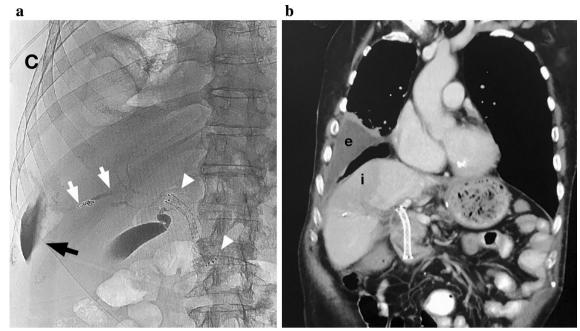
a Final image post-stent placement (white arrowheads) and tract sealing (white arrows). Black arrow points at the opacified right pleural sulcus. C: pleural drainage catheter. b Coronal CT reconstruction of the chest and upper abdomen two months post-intervention shows stent in place and no biliary dilatation. There is residual right pleural effusion (e) and a right hepatic parenchymal infarct (i) from right portal vein thrombosis
